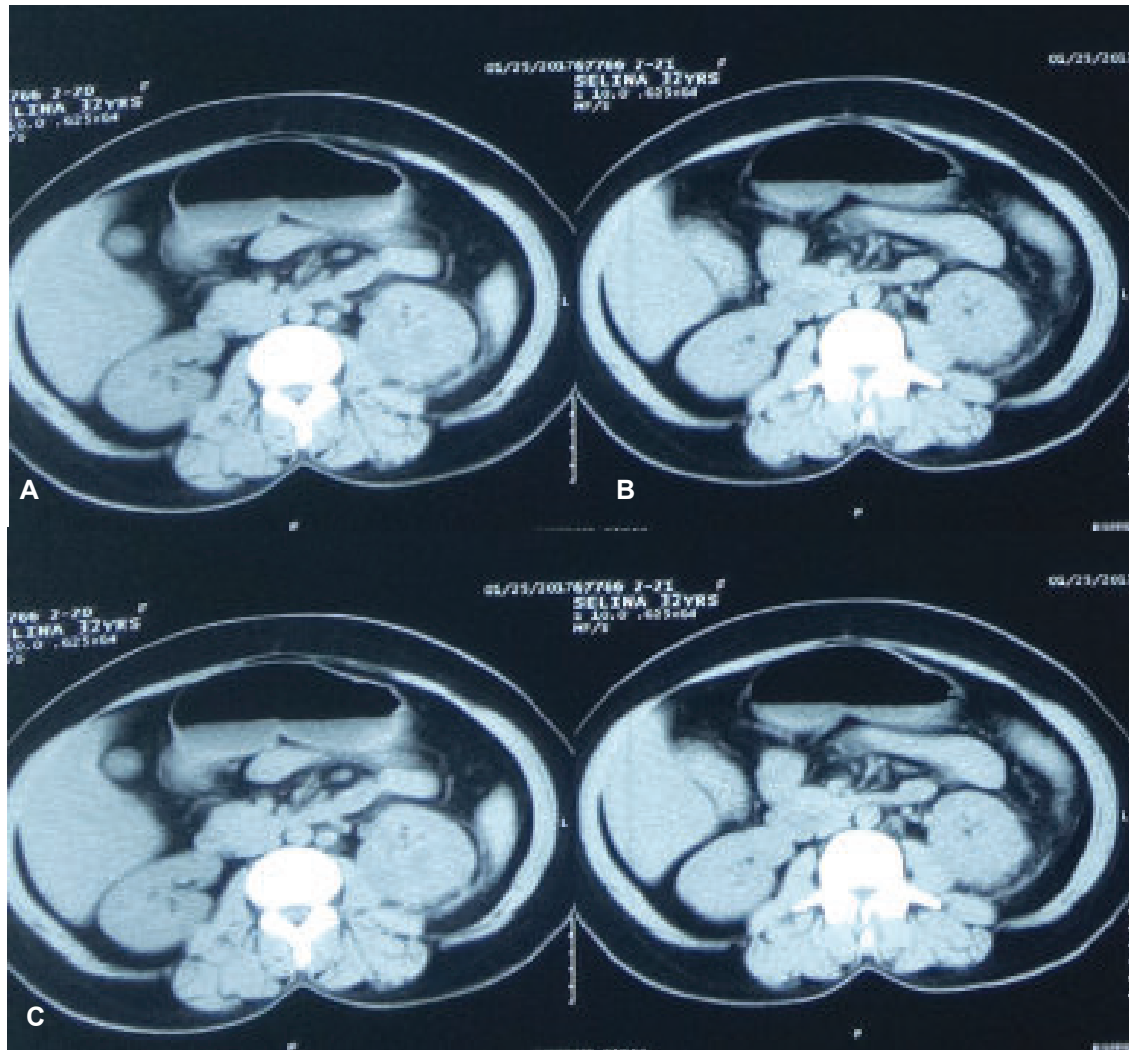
A and B, Precontrast (A) and postcontrast (B) axial CT images through the left lower part of the kidney show the heterogeneously enhancing renal mass with perinephric infiltration (C) Coronal reformatted CT image in the excretory phase better delineates the mass arising from the lower part of the left kidney.
